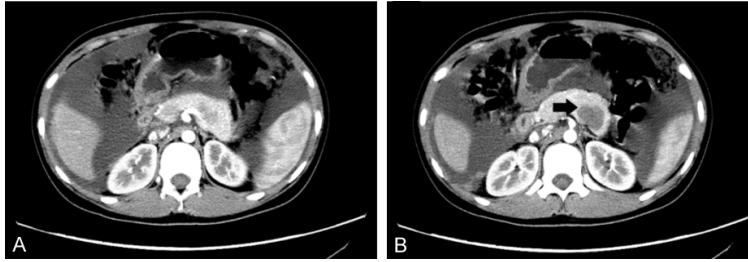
Contrast-enhanced computed tomography (CT) revealed a large volume of ascites (A), and a well-circumscribed mass (black arrow) in the pancreatic body, which showed mildly contrast enhancement on arterial phase (B).
